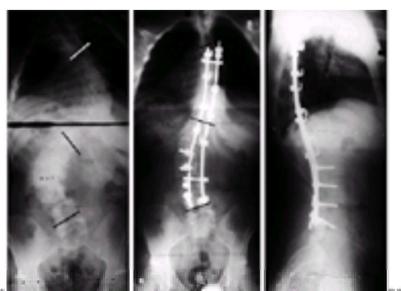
A: This 16-year-old male presented with severe double major scoliosis, with a right thoracic curve of 93 degrees and a left lumbar curve of 85 degrees. On side-bending radiographs to the right, the thoracic curve decreased to 68 degrees. On side-bending to the left the lumbar curve corrected to 52 degrees. B: The patient underwent a thoracoscopic anterior spinal release from T5 to T12, followed by a posterior spinal instrumentation and fusion of both curves. The lumbar curve was corrected to 36 degrees with pedicle screw fixation on the convex side of the curve. Coronal balance was maintained with correction of the thoracic curve to 42 degrees. C: The lateral radiograph demonstrates restoration of alignment in the sagittal plane.
